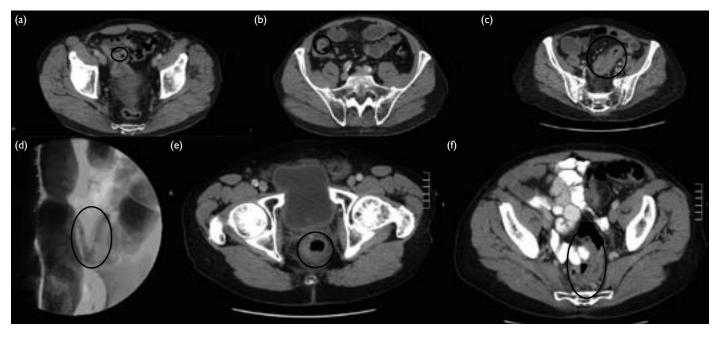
Computed tomographic scans
